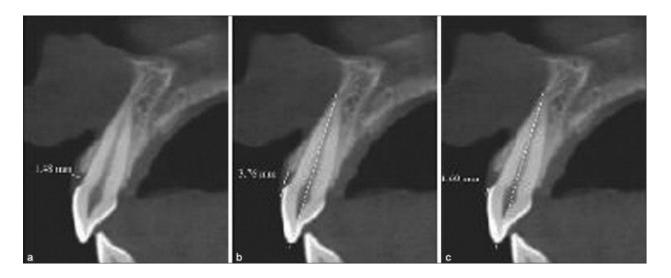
SOFT TISSUE CONE-BEAM COMPUTED TOMOGRAPHY MEASUREMENTS (ST-CBCT) (JANUÁRIO *ET AL.*, 2008).
